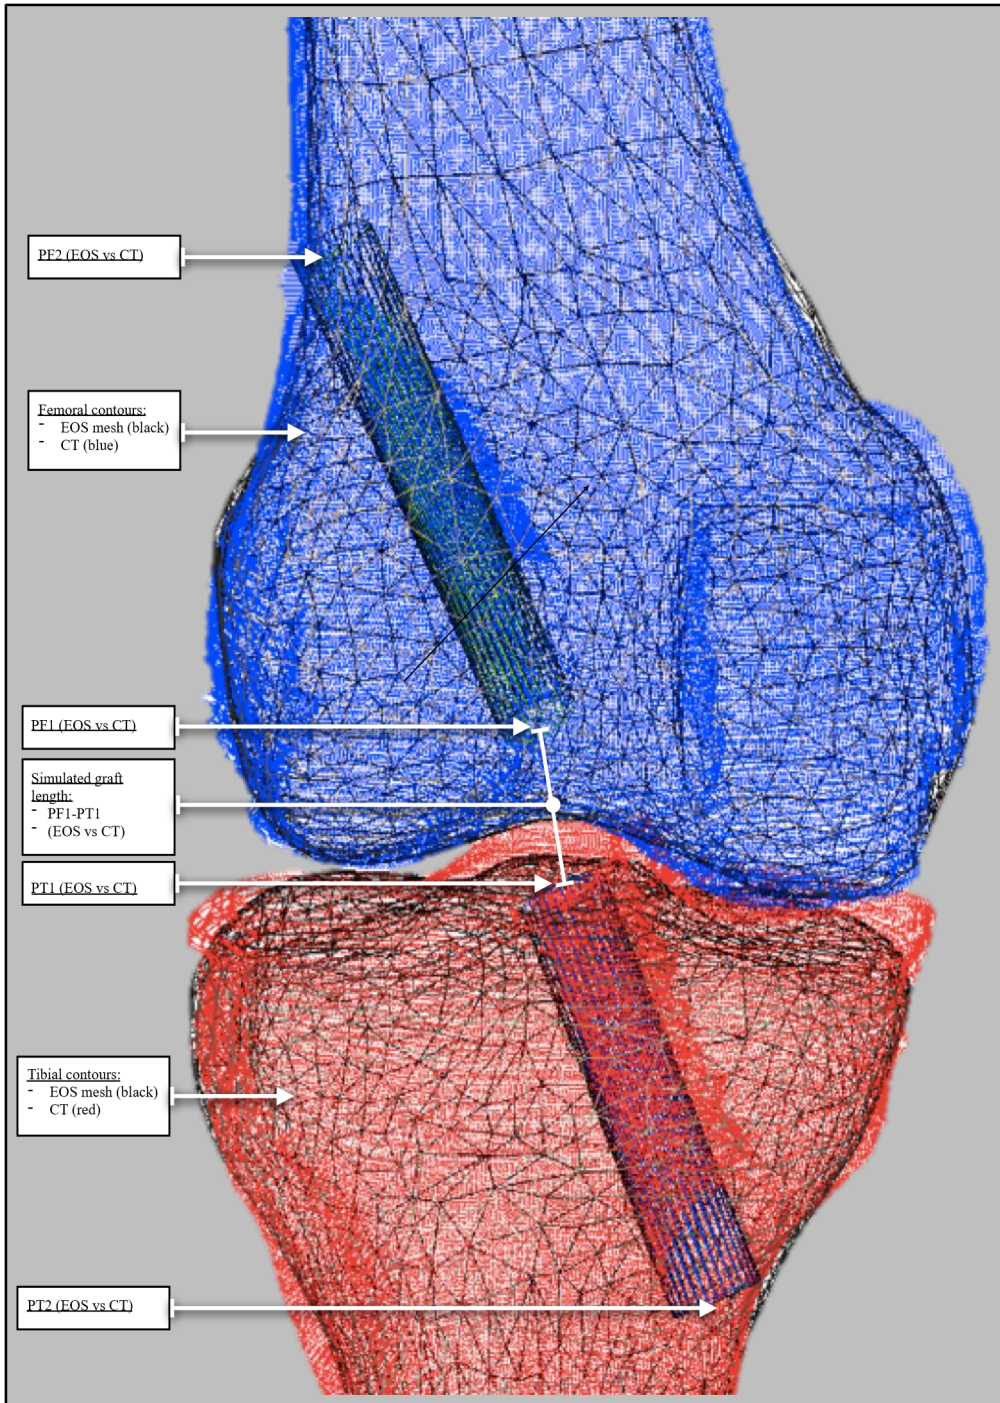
EOS & CT models superposition with tunnels parameters
